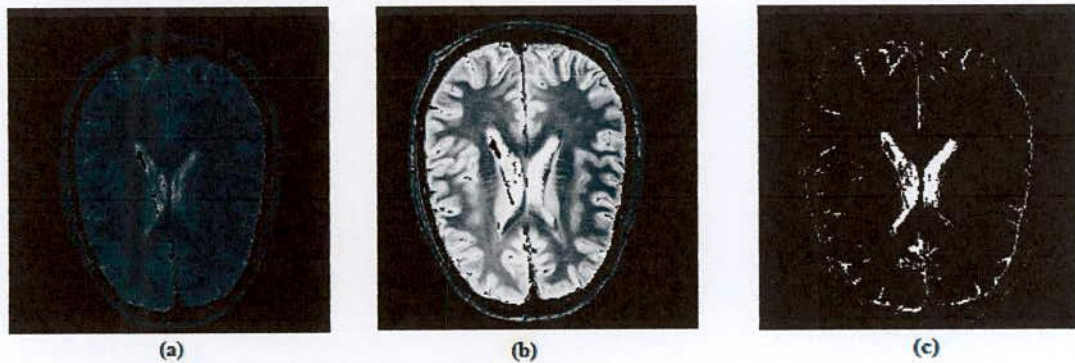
Thresholding based segmented brain MRI image. (a) Original spin density image (b) Enhanced image by histogram equalization (c) Segmented image (CSF tissue) 70 – 230. [Source: .ppt image segmentation region growing & contour following]
